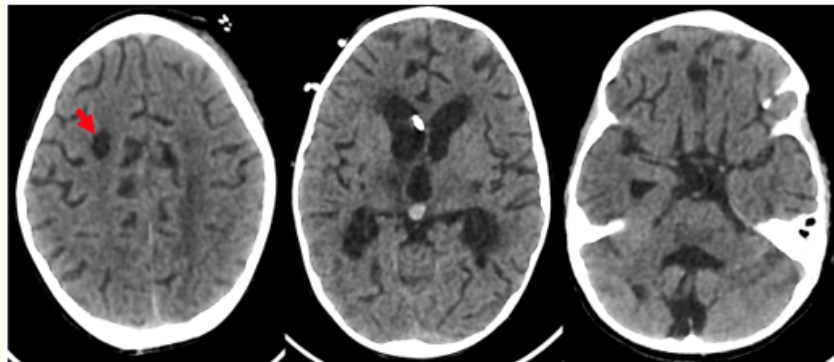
Follow-up brain CT scan at 1 month showing the development of cystic fluid-filled cavities in the bilateral frontal white matter (red arrow), right occipital region, bilateral periventricular parietal regions, and bilateral cerebellar hemispheres, associated with cerebral edema and active shunted quadriventricular hydrocephalus, with persistence of the previously described necrotizing encephalitis lesions.
